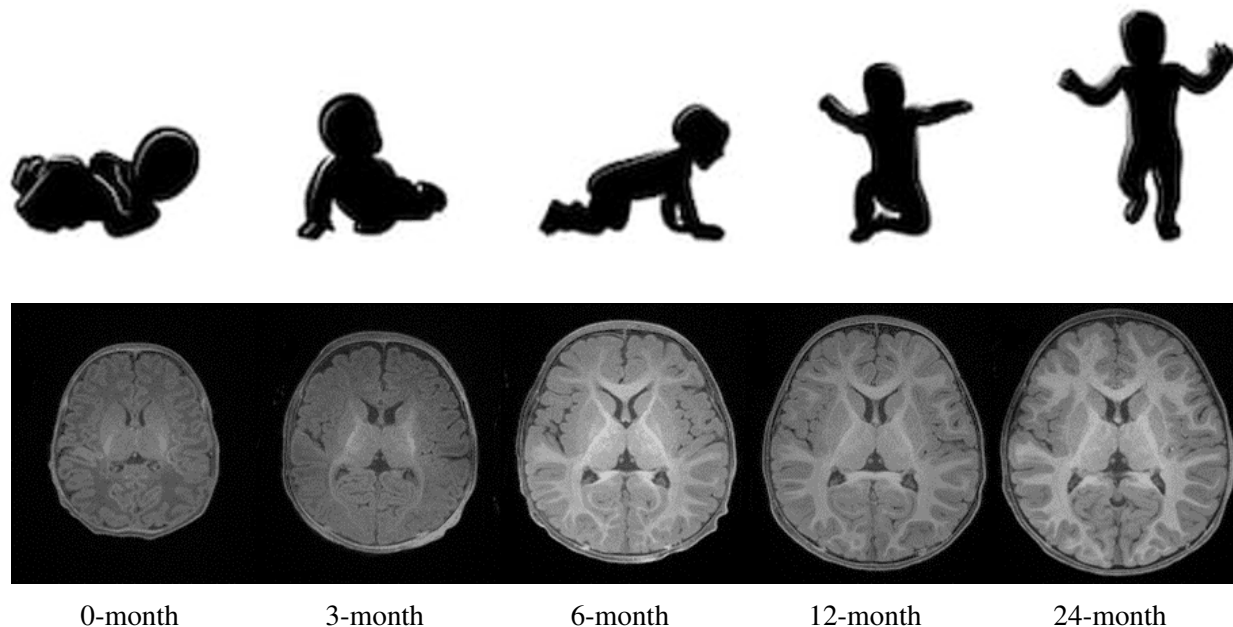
T1-weighted brain images of a typically-developing infant, scanned longitudinally at 0, 3, 6, 12, and 24 months of age. Longitudinal MRI scans allow researchers to study the first year of life, leading to critical insights into many neurodevelopmental and neuropsychiatric disorders.
